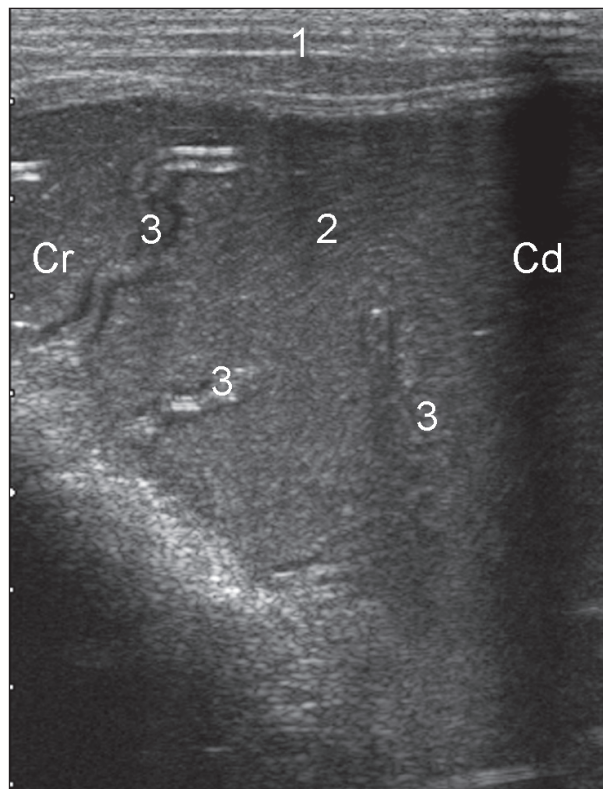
Ultrasonogram of the abomasum of a calf during feeding. A 5.0 MHz linear transducer was used to scan the ventral abdomen. The ingested milk has not clotted yet and appears as a homogeneous mass. The abomasal folds are clearly visible. 1 Ventral abdominal wall, 2 Milk that has just entered the abomasum, 3 Abomasal folds, Cr Cranial, Cd Caudal.
